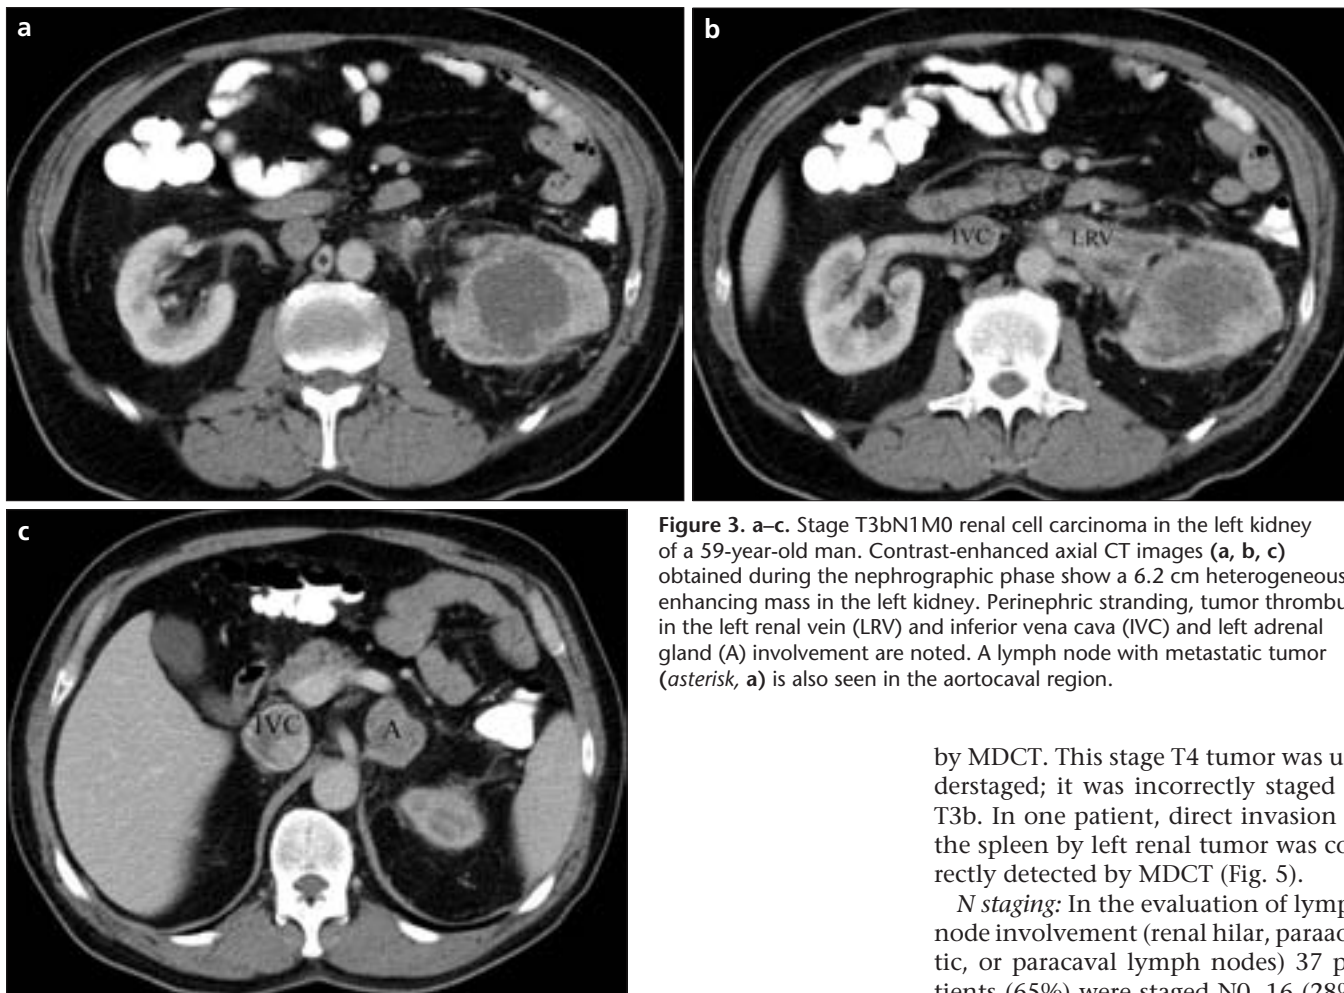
a–c. Stage T3bN1M0 renal cell carcinoma in the left kidney of a 59-year-old man. Contrast-enhanced axial CT images (a, b, c) obtained during the nephrographic phase show a 6.2 cm heterogeneously enhancing mass in the left kidney. Perinephric stranding, tumor thrombus in the left renal vein (LRV) and inferior vena cava (IVC) and left adrenal gland (A) involvement are noted. A lymph node with metastatic tumor (asterisk, a) is also seen in the aortocaval region.
